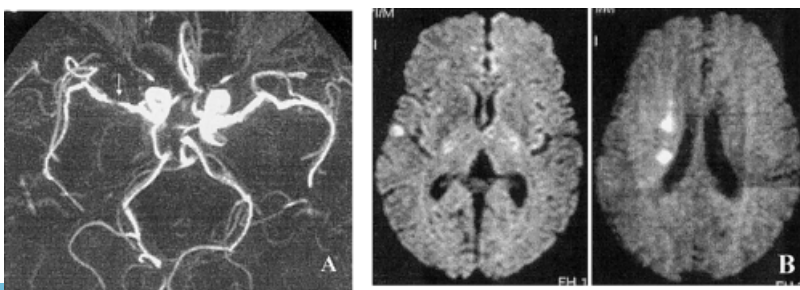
A 57-year-old man had left-sided weakness. (A) Magnetic resonance angiography showed severe right middle cerebral artery stenosis. (B) Diffusion-weighted magnetic resonance imaging showed multiple chainlike small infarcts in the internal border zone region (right panel) and a small infarct in the temporal cortex (left panel).
